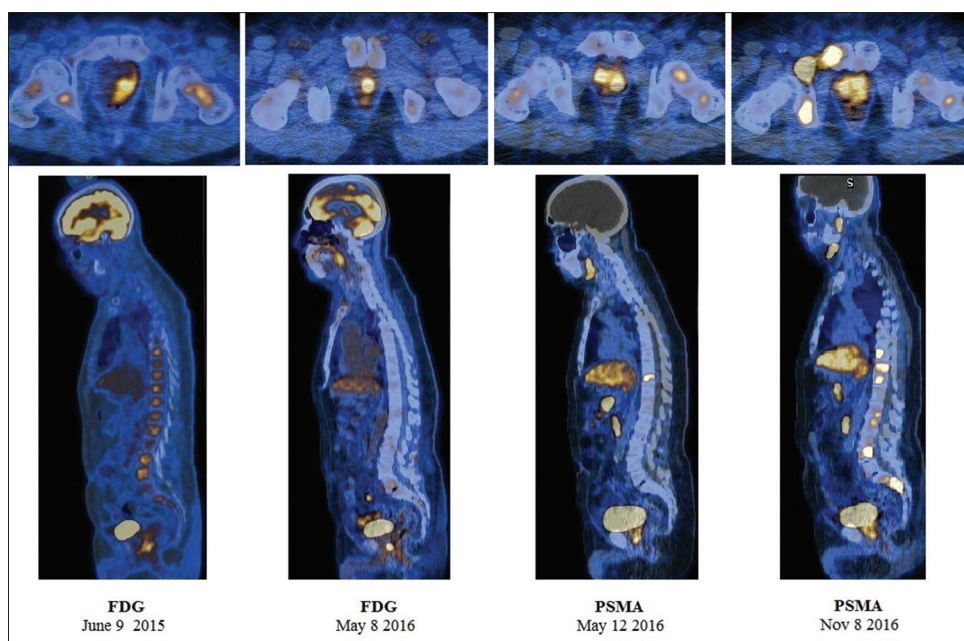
Selected transaxial and sagittal fluorodeoxyglucose and prostate-specific membrane antigen positron emission tomography/computed tomography fusion images demonstrating uptake in the prostate gland and bones
